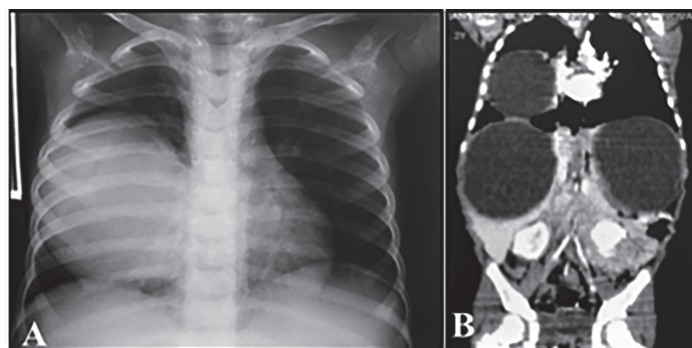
Anteroposterior chest radiograph (A) and coronal thoracoabdominal computed tomography scan (B) revealing large combined cystic masses in both the thoracic and abdominal cavities.
